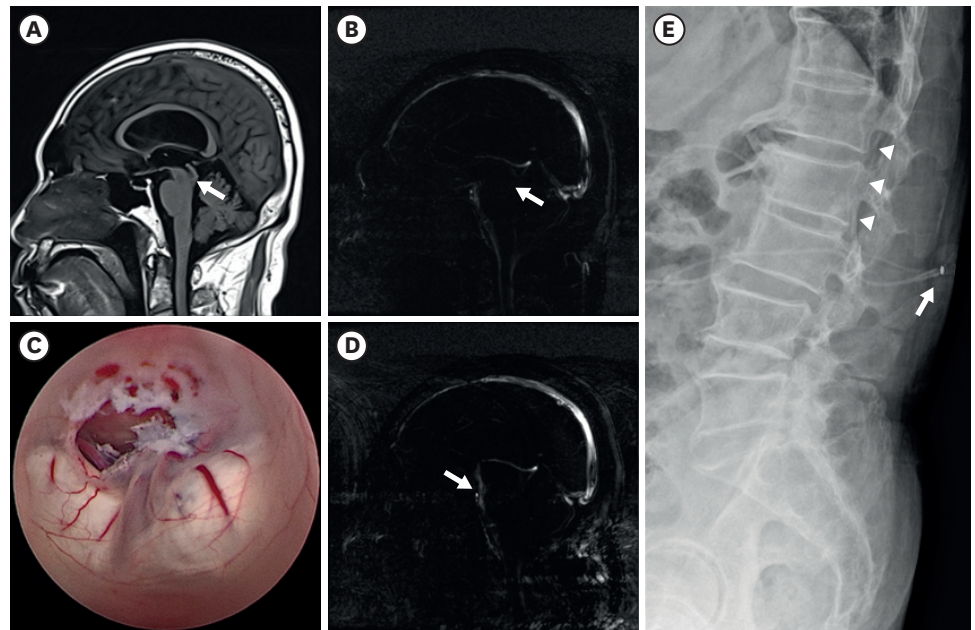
Radiographic and surgical images of a patient with complex hydrocephalus. (A) Sagittal image of the preoperative brain MRI showed aqueductal stenosis and upstream hydrocephalus (arrow). (B) No flow through the aqueduct of Sylvius was observed on CSF flow dynamic MRI (arrow). (C) Endoscopic third ventriculostomy was performed through the tuber cinereum. (D) CSF flow dynamic MRI performed after ETV showed good CSF flow through the ETV site (arrow). (E) After performing the LPS, a proximal catheter (arrowhead) inserted at the L2-3 level and the shunt valve (arrow) were seen on a lumbar spine X-ray. MRI: magnetic resonance imaging, CSF: cerebrospinal fluid, ETV: endoscopic third ventriculostomy, LPS: lumboperitoneal shunt.
